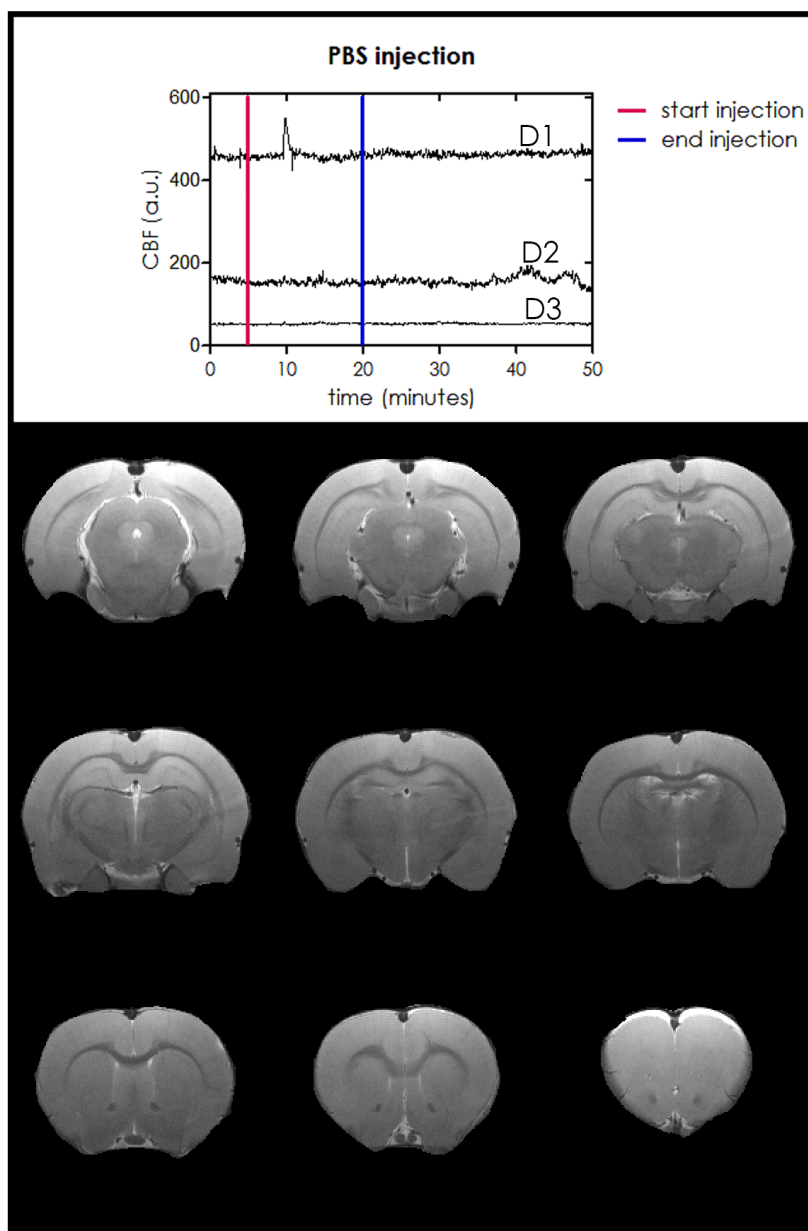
CBF for 3 Doppler probes (D1, D2, D3) measured before, during and after the injection of PBS; and MR T₂ weighted images of several slices 24h after the injection.
